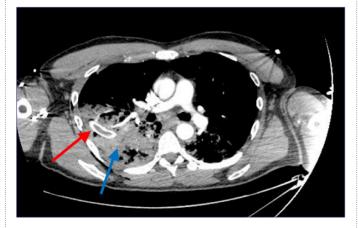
This axial slice of the thoracic CT scan performed shows evidence of extensive pulmonary contusion (blue arrow) within the right lung field. The chest drain is also visible (red arrow).
